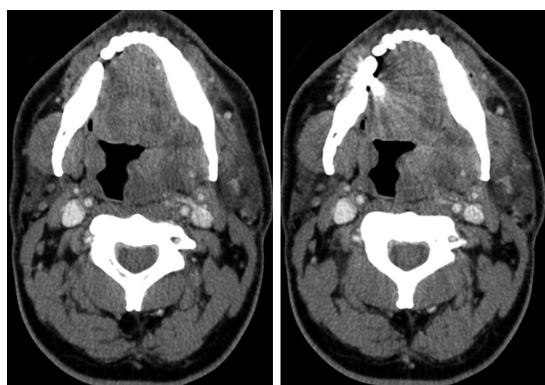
Axial computed tomography images at the level of the oropharynx prior to incision, drainage and silver nitrate application demonstrate swelling and enlargement of the left palatine tonsil and peritonsillar tissues with heterogeneous relatively low attenuation areas.
